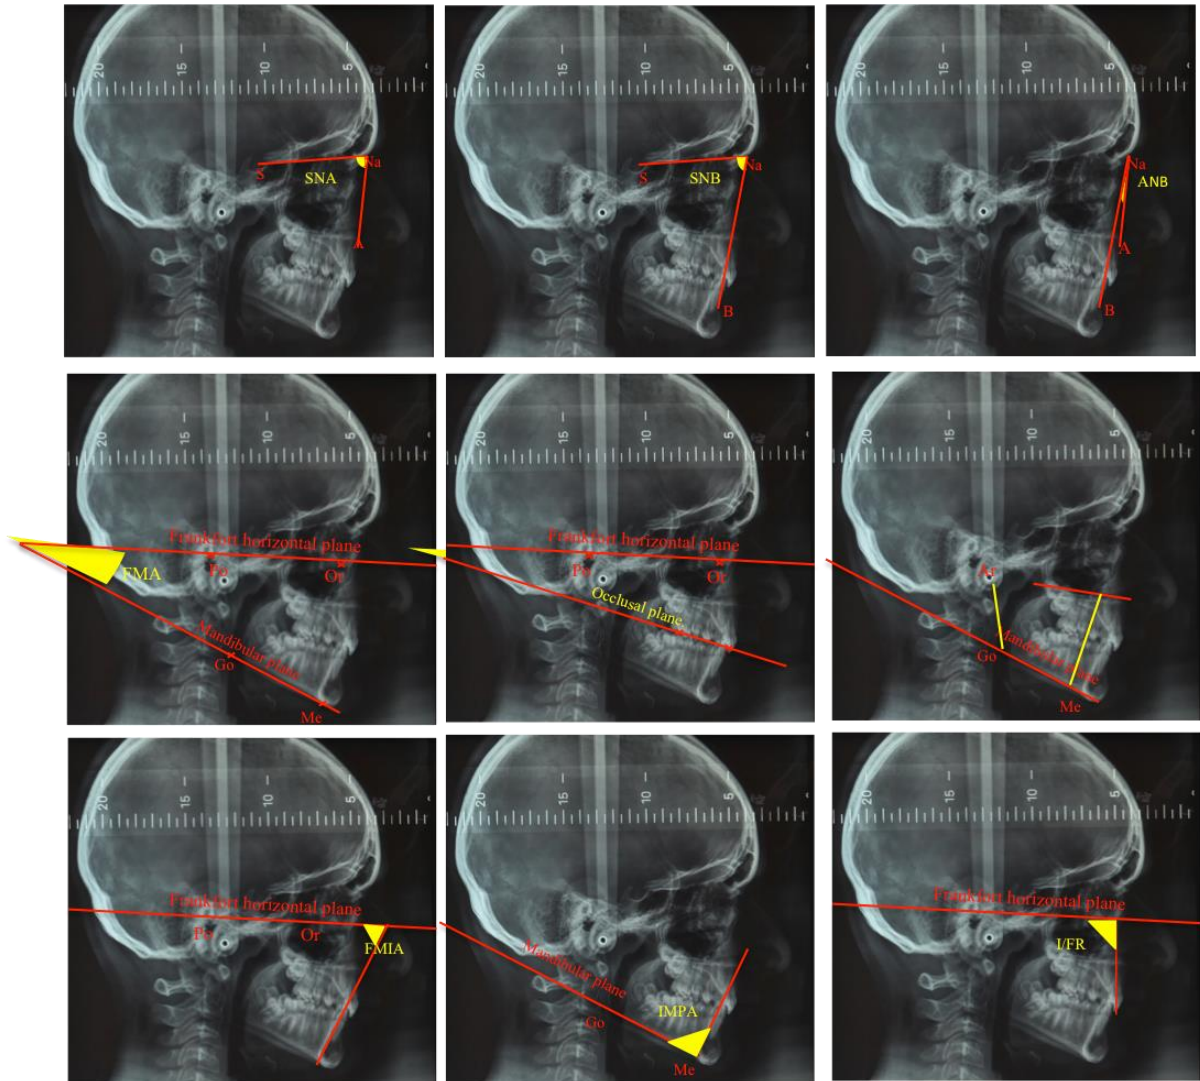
Cephalometric radiography measurements considered for the clinical study and growth evaluation.
